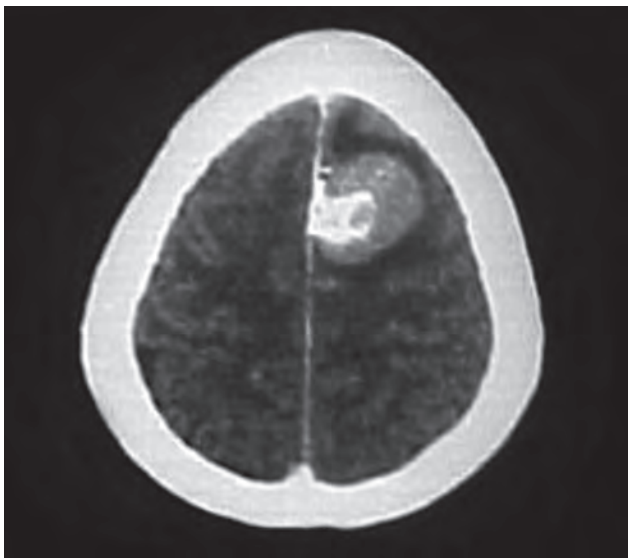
CT scan showing an anterior-third falx meningioma
